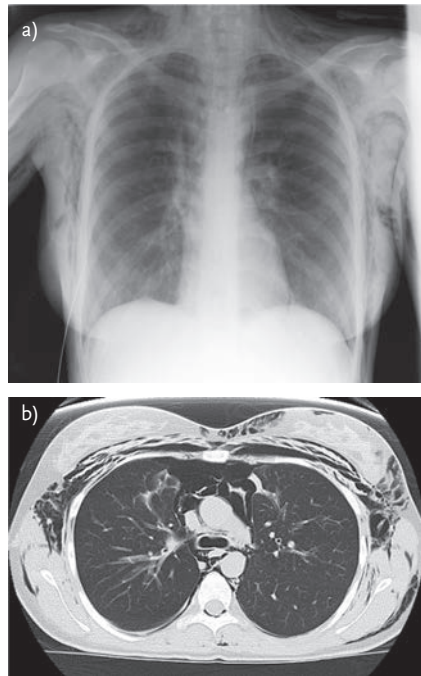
Pneumomediastinum. a) Radiograph and b) CT.
